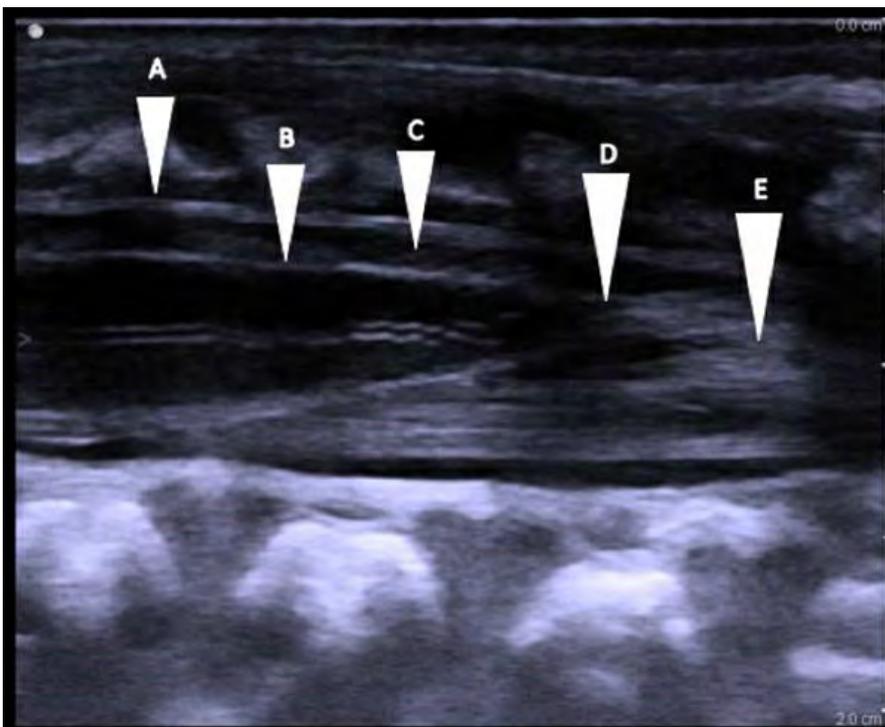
Longitudinal lumbar sonogram. (A) Dura; (B) Spinal Cord; (C) CSF; (D) Conus Terminalis; (E) Cauda Equina.
